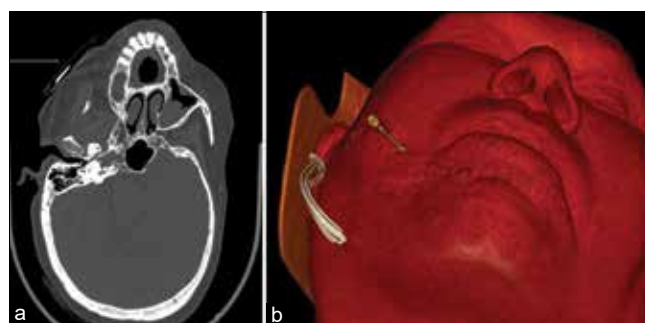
Computed tomography axial view (a) and three-dimensional volume-rendered reformat (b) showing dense radio marker (blue arrow); lateral head tilt positioning along with the site of needle entry
